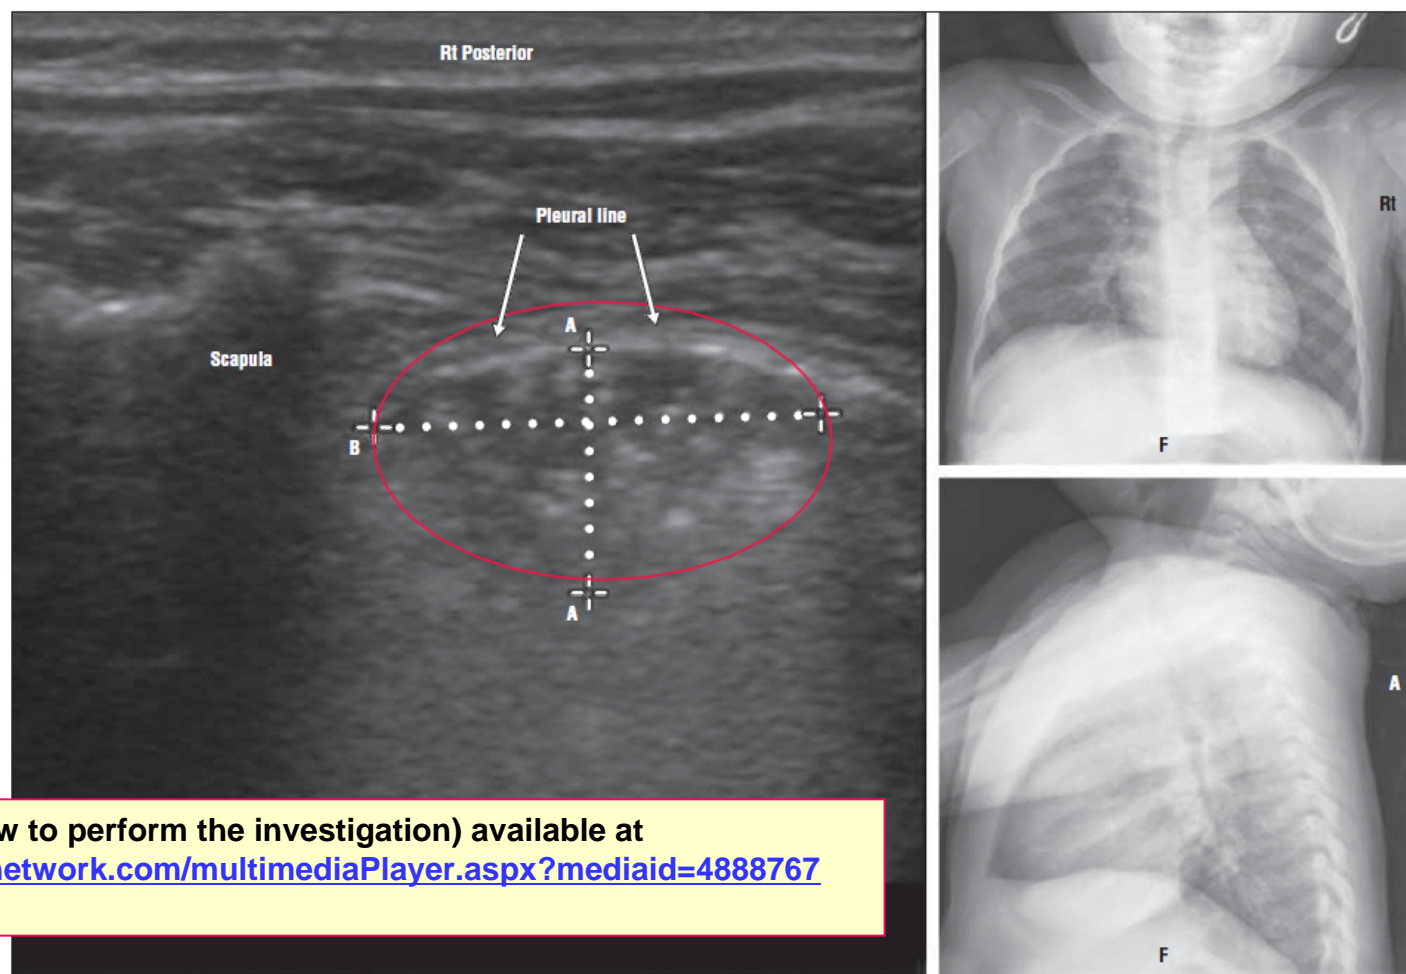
Lung consolidation of 1 cm or less with sonographic air bronchograms on ultrasonography not detected by chest radiography. F indicates frontal view; RT, right; and red oval, lung consolidation. A is caliper A measurement, and B is caliper B measurement.
